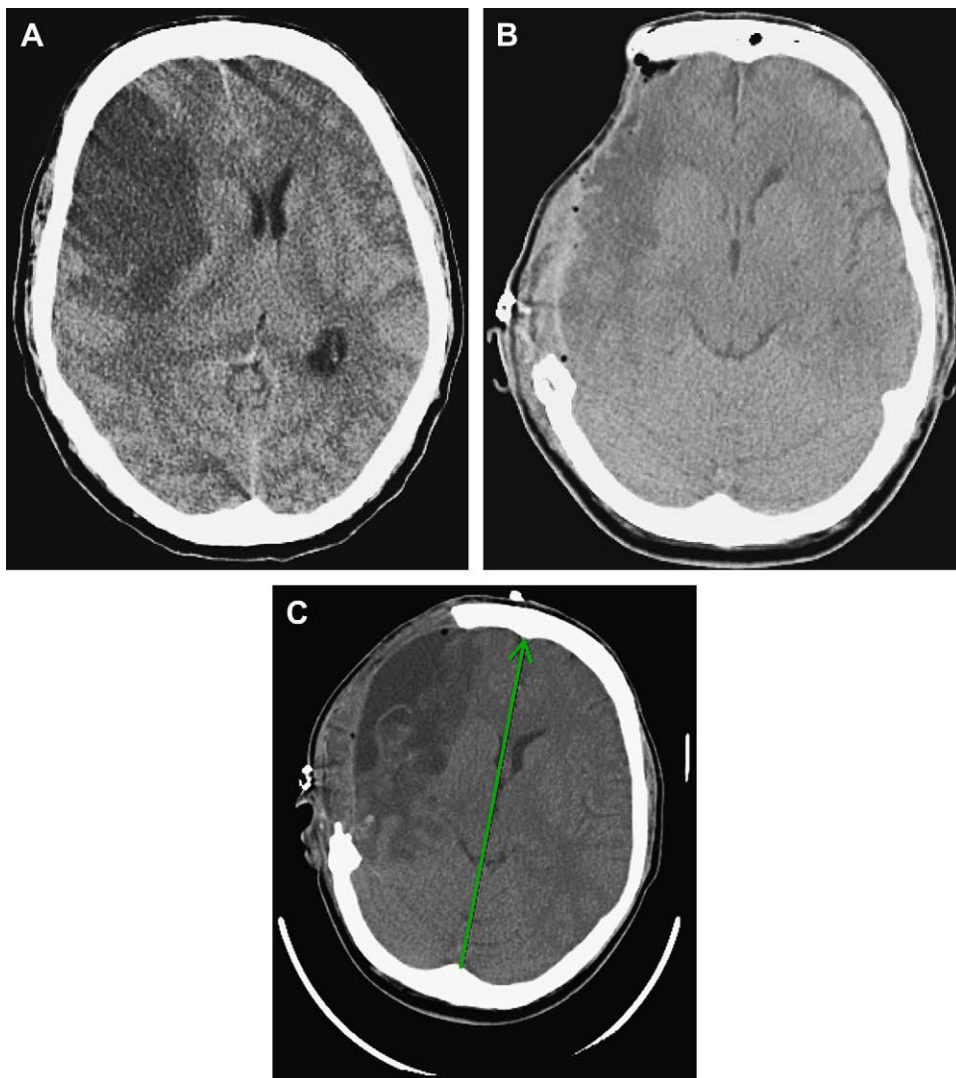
(A) CT scan of a 50-year-old, right-handed man who had right internal carotid artery occlusion and who presented with acute onset of dysarthria, right gaze preference, left facial droop, left hemiplegia, and left hemianesthesia. Over the next 2 days, he had a decline in the level of consciousness. The preoperative CT demonstrates a right frontal infarction with subfalcine herniation. (B) Postoperative scan from the day after craniotomy. The patient had been taken urgently to the operating room, where he had a large frontal-temporal-parietal-occipital craniotomy, and the bone over the temporal tip was removed completely, decompressing the temporal tip. The dura then was opened circumferentially. The brain came out under pressure. At this point, a right temporal and right frontal lobectomy was performed, removing approximately 6 cm of the temporal lobe and approximately 8 cm of the frontal lobe. This allowed significant reduction and mass effect. Thereafter, synthetic dural material was laid over the top of the brain with the dura having been tented back circumferentially over Oxycel for hemostasis. (C) CT scan 5 days after craniotomy showing outward swelling of the brain with resolution of the right to left ventricular shift.
